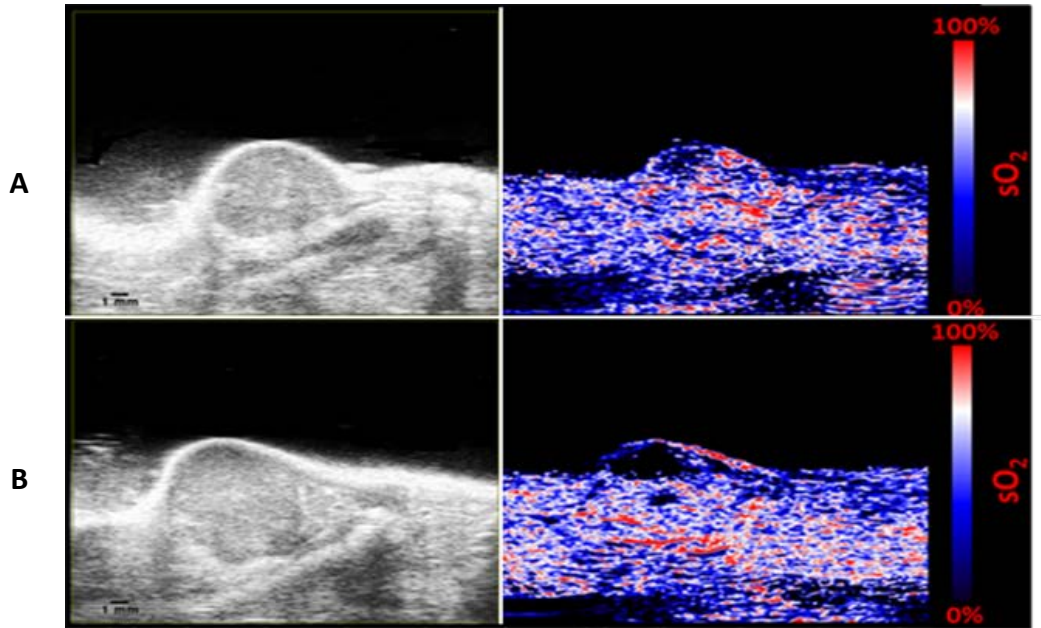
4: Ultrasound and Photoacoustic images from a HCC-NTC tumour, A (i,ii) and compared to a HCC-379 tumour, B (i,ii). Images taken in the range of 680 – 970 nm allowing for detection of oxy and deoxyhaemoglobin
